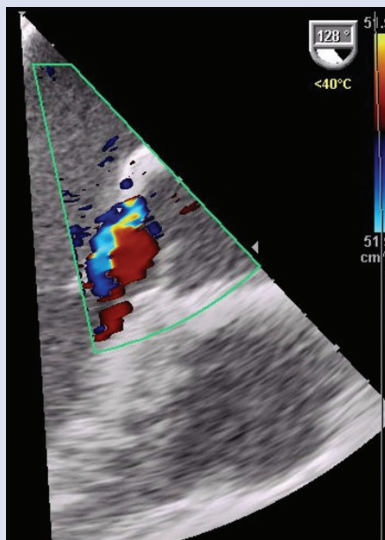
Transoesophageal echocardiography — screening modified. Colour-labelled study showing a leak between the ruptured aneurysm of the sinus of Valsalva and the right atrium
